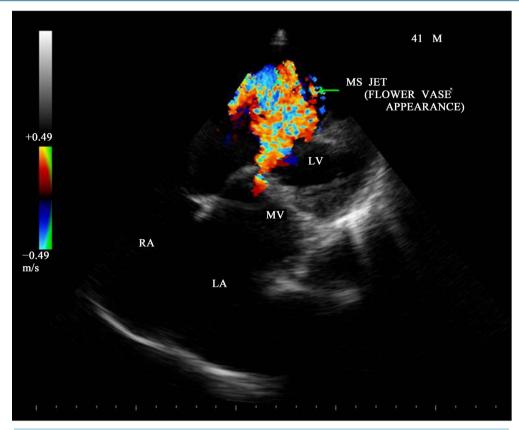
Apical four chamber view-showing the MS jet—"flower vase appearance".
